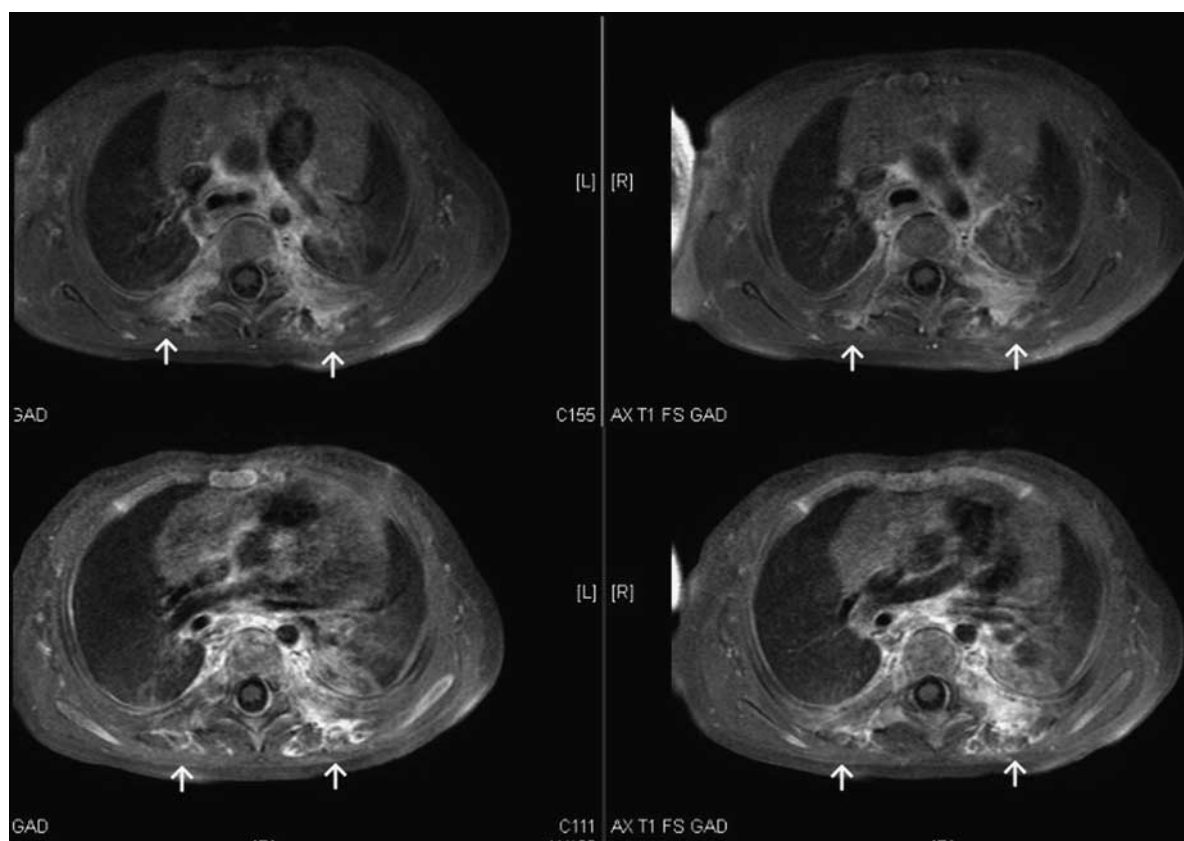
Follow-up gadolinium T1 fat-suppressed magnetic resonance imaging images show a persistent lesion (arrows) that is less extensive and less infiltrative.
